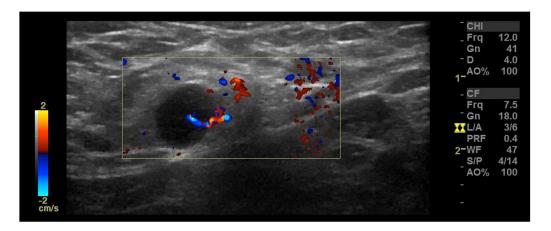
The targeted ultrasound of the left breast is extended to the left axilla. There is a single enlarged lymph-node with sonographic morphologic characteristics that are suspicious for metastatic involvement. These include a round shape, loss of the fatty hilum and abnormal blood flow.
